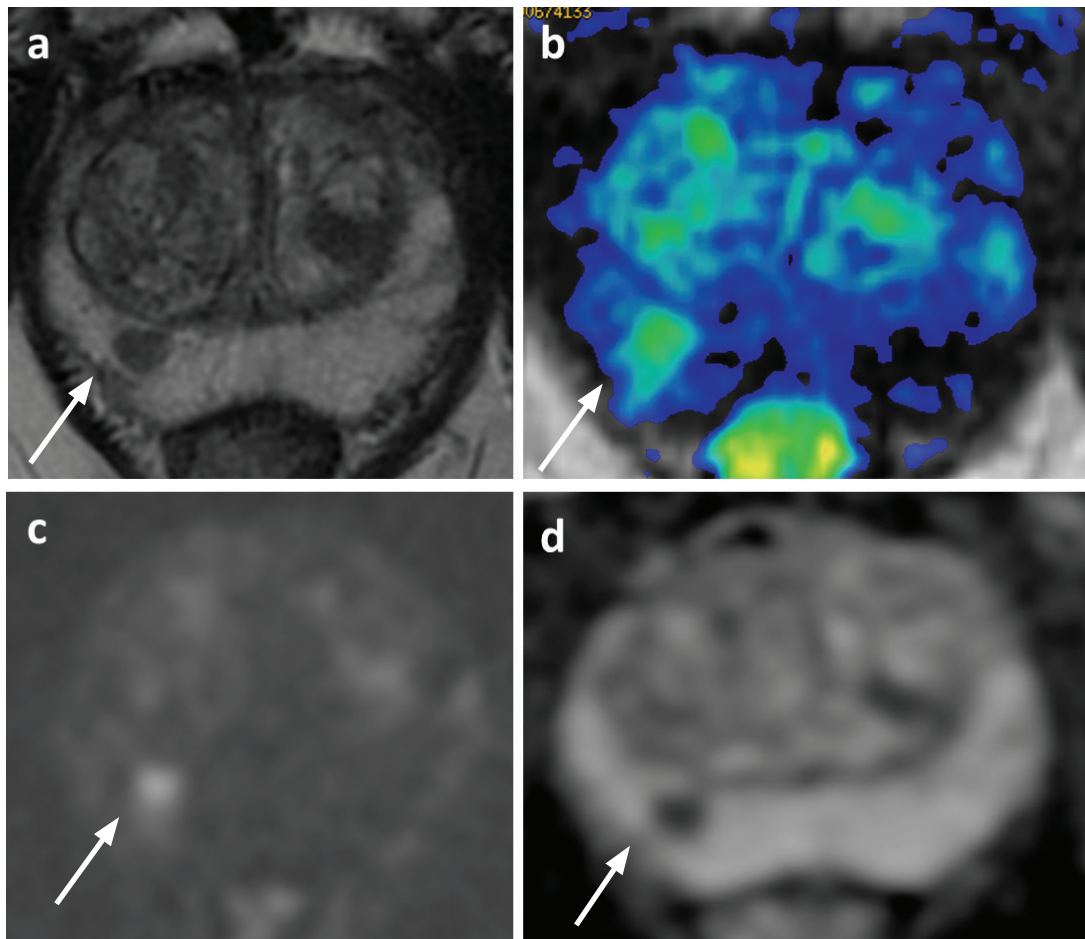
Prostate MRI pitfall: ectopic BPH nodule (arrow). (a) T2WI, right peripheral zone posterolateral lesion with sharply-defined margins, round shape and surrounded by a subtle pseudocapsule. (b) at the same level early enhancement on colorimetric map of DCE MRI. (c-d) at the same level hyperintensity on DWI ($b=2000$) and corresponding hypointensity on ADC map. The lesion was classified as PI-RADS 2. BPH, Benign Prostatic Hyperplasia; T2WI, T2-weighted image; DCE, Dynamic Contrast -Enhanced; DWI, Diffusion-weighted image; ADC, Apparent diffusion coefficient.
